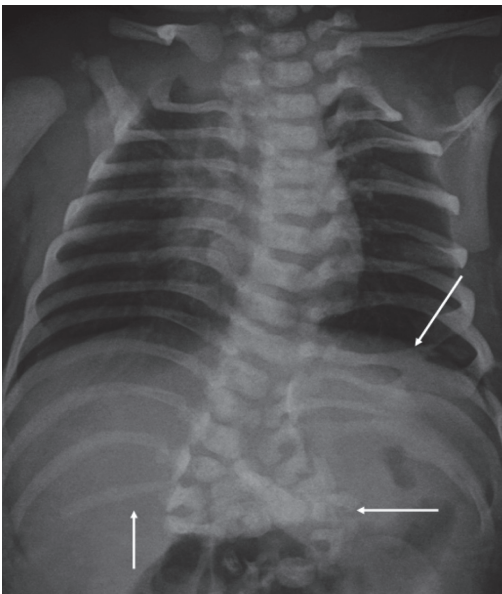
Standard X-ray examination shows supernumerary lumbar vertebrae with failure of formation as hemivertebrae and butterfly vertebrae, forming two columns. The image also shows butterfly vertebrae of the lower thoracic segment of the spine, synostosis of the lower ribs on the left as well as a supernumerary 13th rib on the right.
